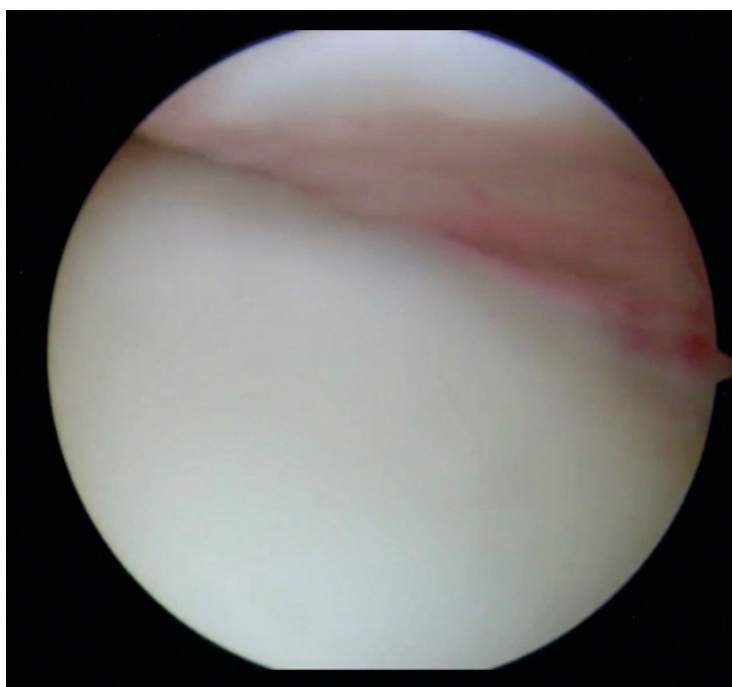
The mattress sutures draw the infraspinatus and the posterior capsule to the abraded bony surfaces, thus achieving a filling (remplissage) of the Hill-Sachs lesion (5 A). MRI aspect of remplissage 3 months after the procedure (5 B).
